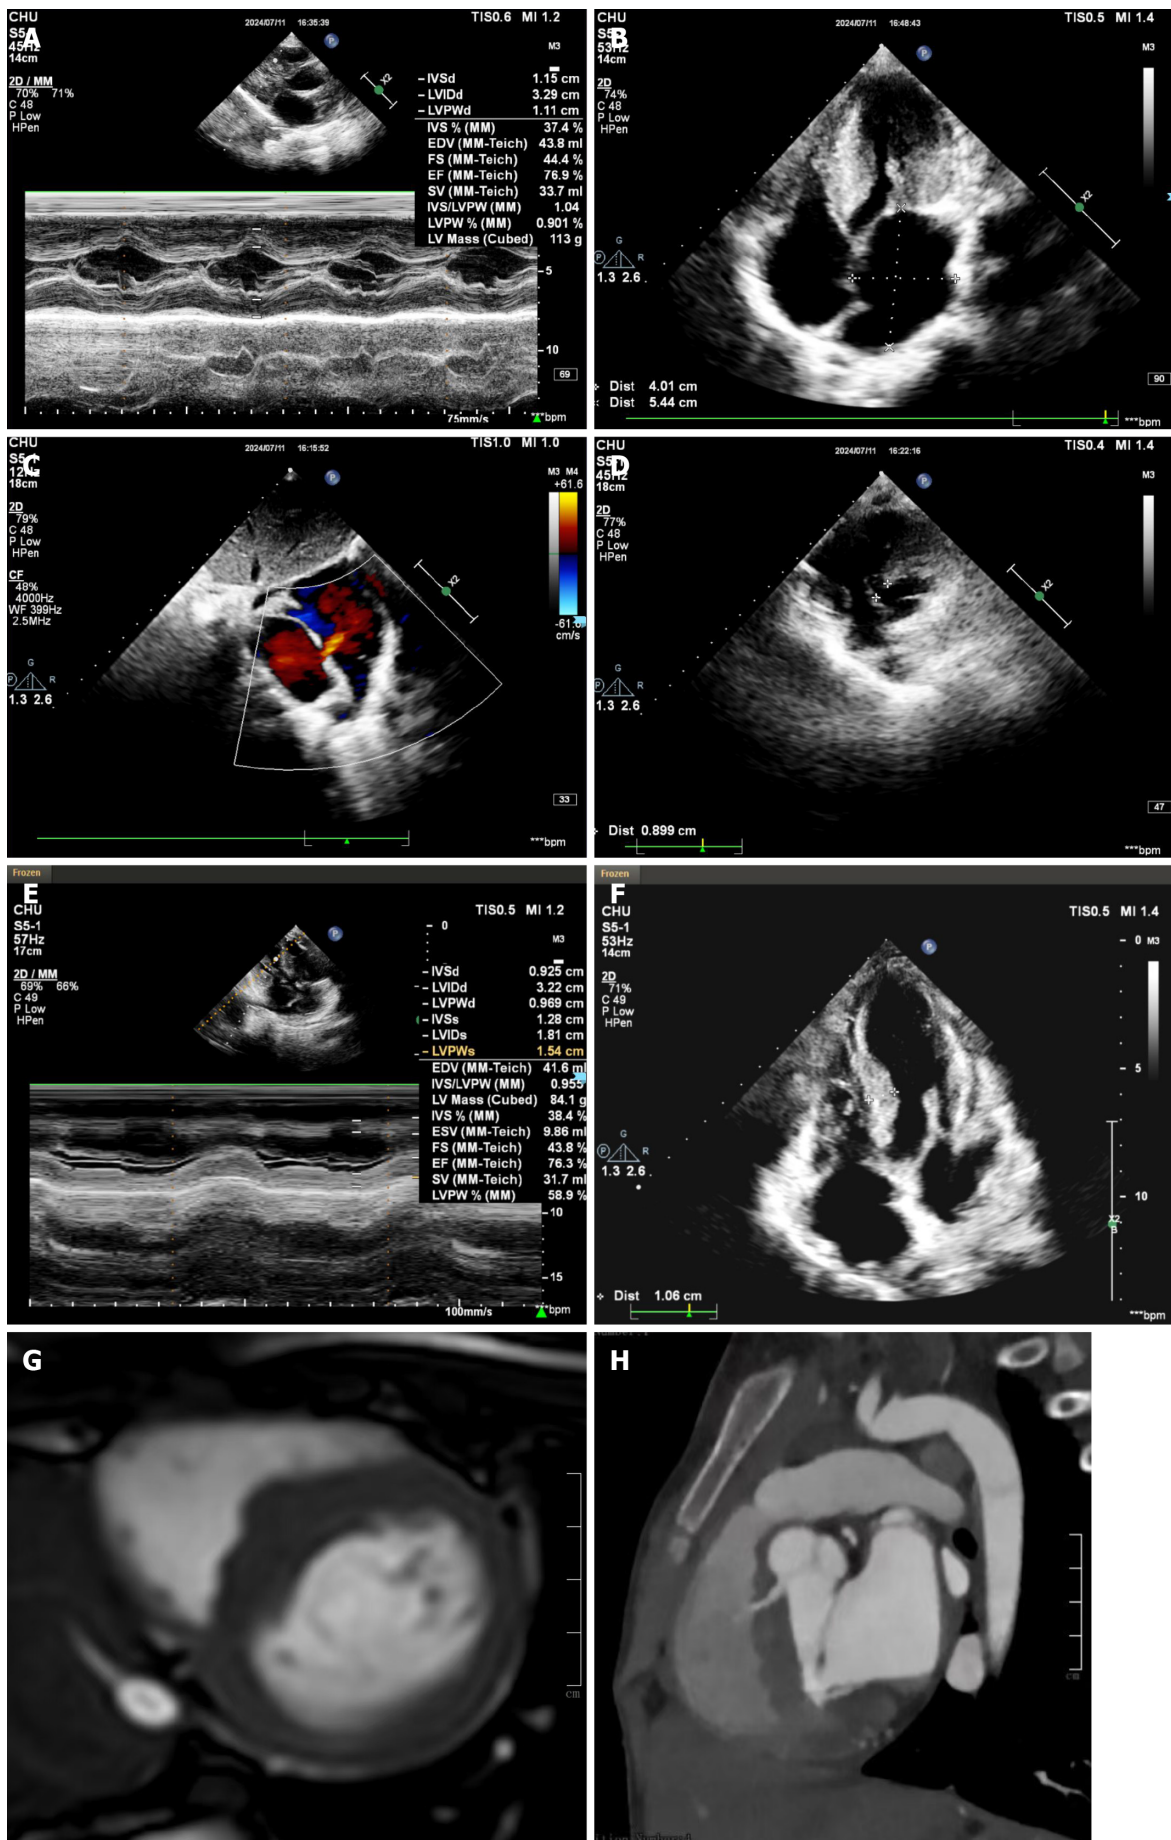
Echocardiographic and cardiac magnetic resonance imaging findings: from pre-operative diagnosis to post-discharge
